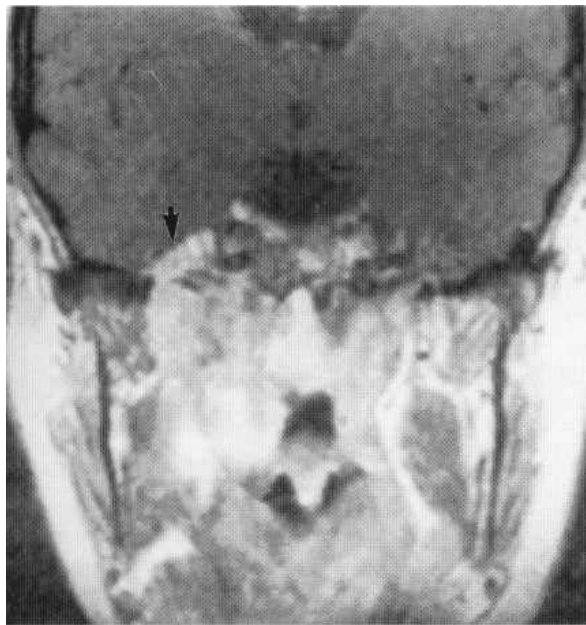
Coronal Gd-MRI section showing an adenoid cystic carcinoma of the nasopharynx which has eroded the skull base in the region of the foramen lacerum and extended up into the parasellar area (arrow). This intracranial extension could only be fully appreciated on the enhanced scan but discrimination of the lower part of the tumour from fat and enhanced mucosa is less certain.
